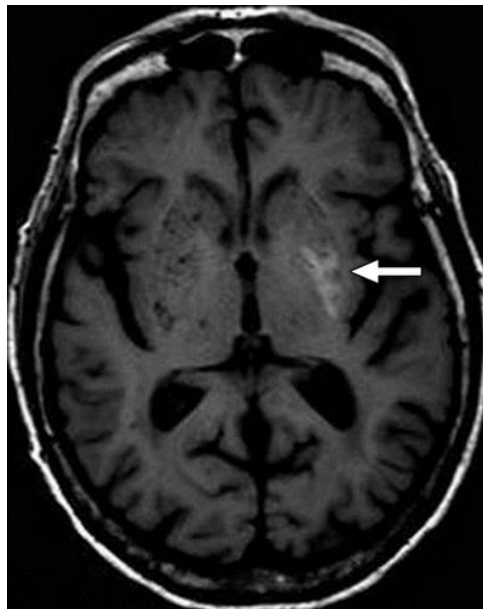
T1 weighted MRI showing hyperintensity in the left lentiform nucleus
